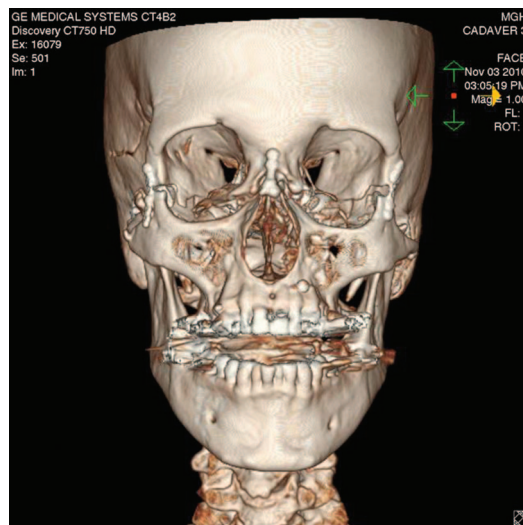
Three-dimensional computed tomographic scan reconstruction of a mock Le Fort III–based maxillofacial allotransplant recently performed at the Massachusetts General Hospital/Harvard Medical School.
